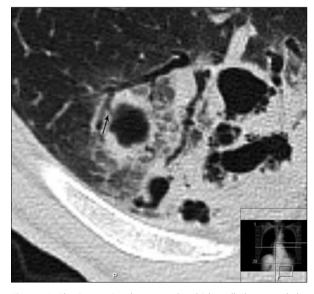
The interaction between the thick walled cyst and the ectatic terminal bronchiole [black arrow] can easily be seen in this magnified HRCT scan. Also note the cysts and bronschiectasis in the consolidation area
